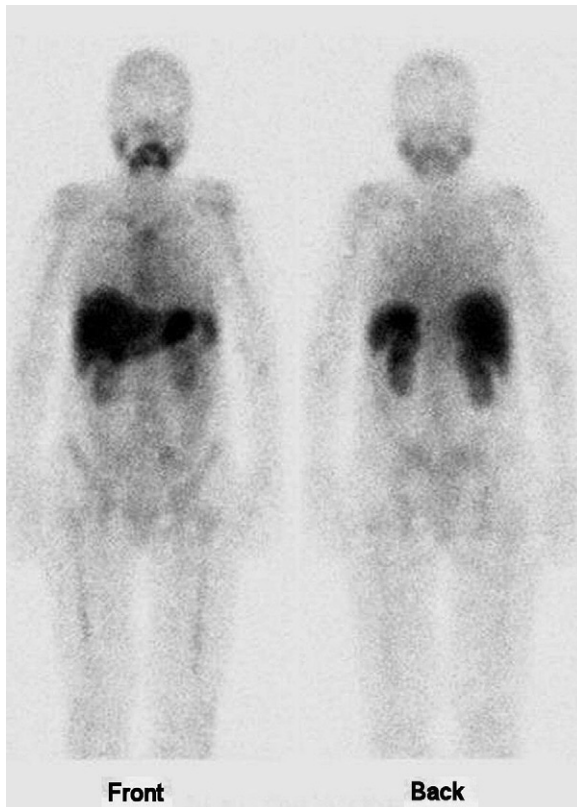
Total body SAP scintigraphy (anterior and posterior images) of a 60-year-old woman with systemic amyloidosis (probably AL type) with increased uptake (++) in the liver, spleen, and kidneys and (+) bone marrow. Minor nonspecific uptake can be seen in the parotid glands, nasopharynx and stomach.
